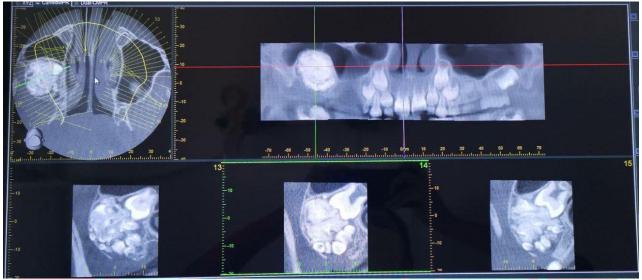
CBCT of the patient
